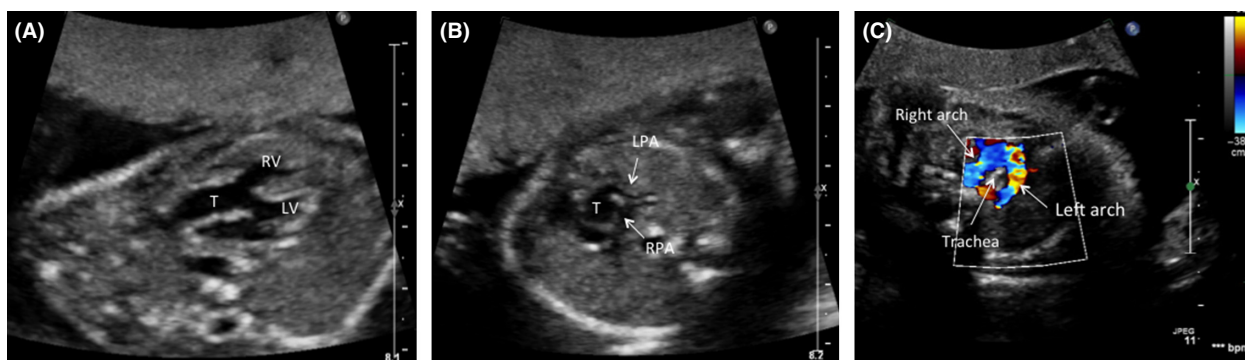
Fetal echocardiogram. (A) Transverse view at the outflow tract level; (B) Short-axis view of common arterial trunk and branch pulmonary arteries; (C) A 3-vessel tracheal view of the double aortic arch with color Doppler. RV, right ventricle; LV, left ventricle; T, common arterial trunk; LPA, left pulmonary artery; RPA, right pulmonary artery.
